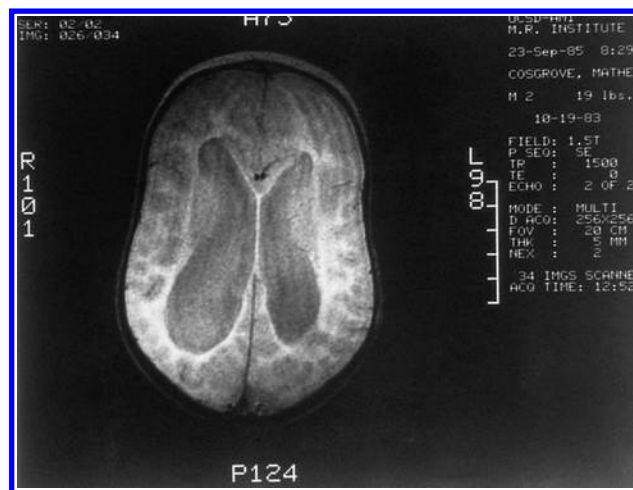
Magnetic resonance image of the brain of the patient in Figure 22.3. Dilated ventricles and sulci indicated a severe loss of volume of brain.
